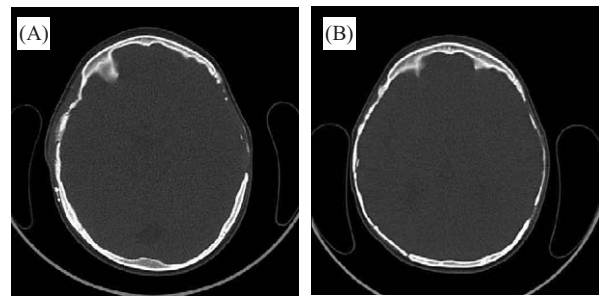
Same patient; axial CT scans: (A) calvarial bone defects preoperatively and (B) three months postoperatively.
